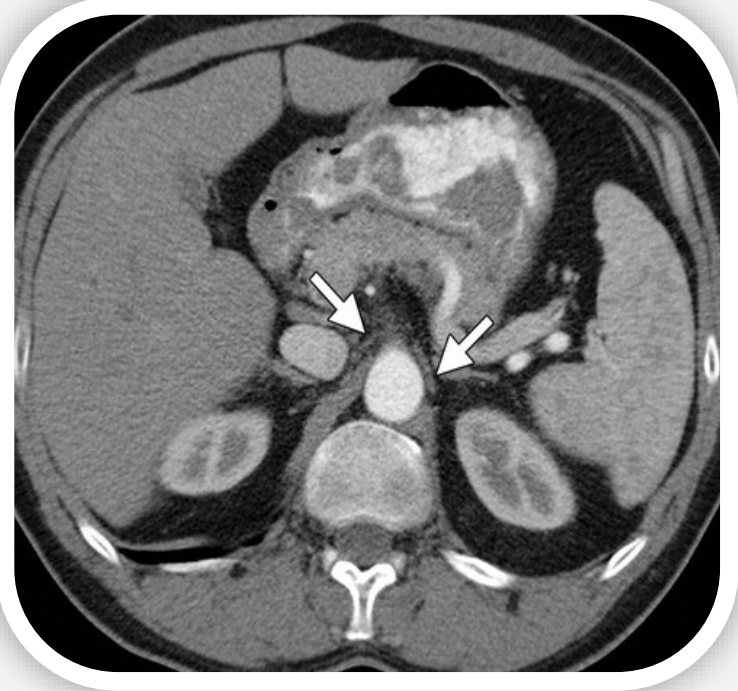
Figure #2: Contrasted CT demonstrating the typical appearance of the celiac plexus
